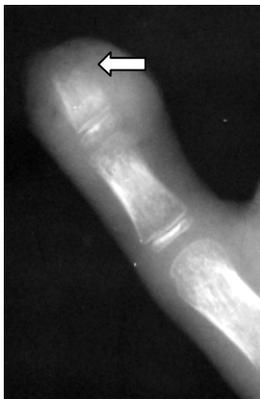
Enlargement radiograph of the first finger of the hand. Osteoporosis, consolidation and increase in soft tissues in area of distal phalanx (a figured arrow) is indicated. It is destruction of a bone of distal phalanx of the first finger (arrow). Panaricium of the first finger of the hand.
